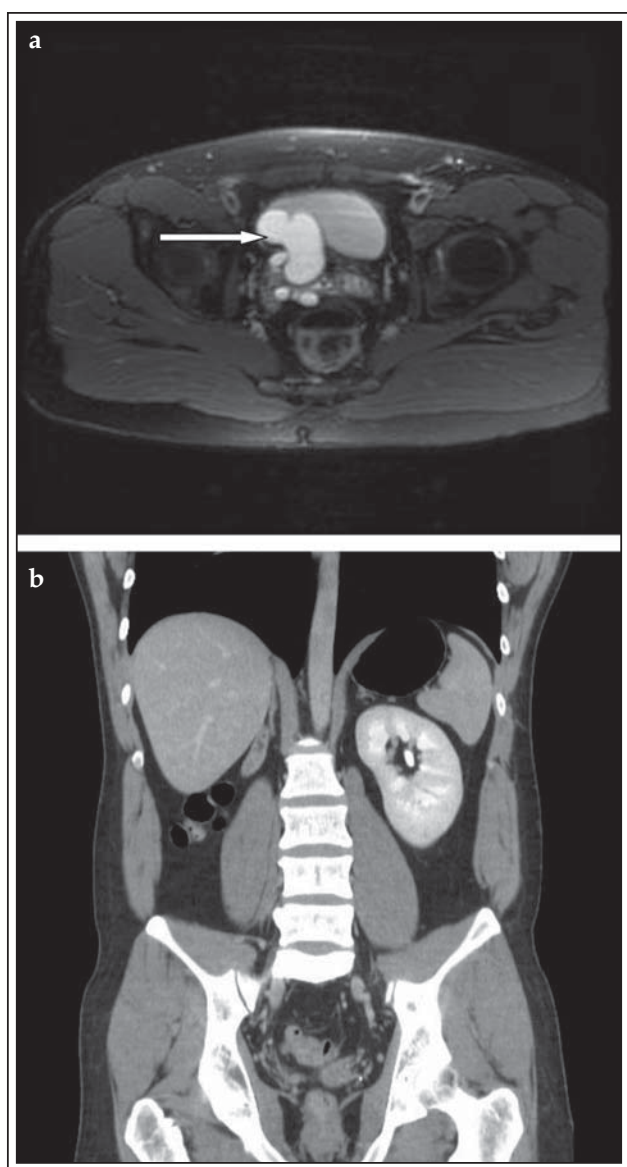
a) MRI, arrow showing right seminal vesicle cyst, b) CT urogram showing absent right kidney.
